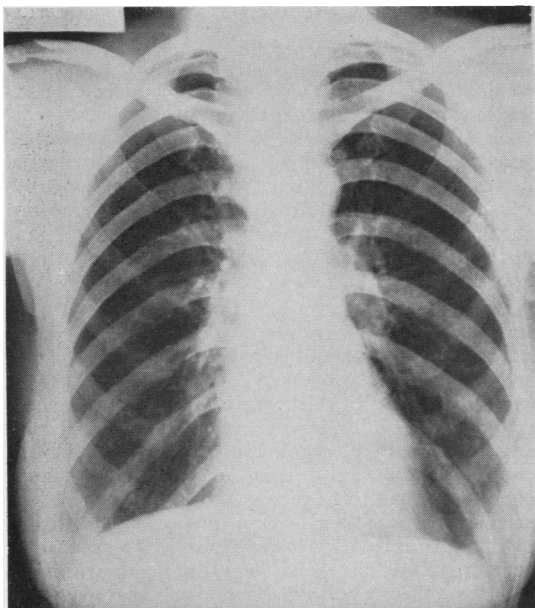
Radiograph of Case 1 on her third admission, showing complete re-expansion of the left lung after bronchoscopy.
